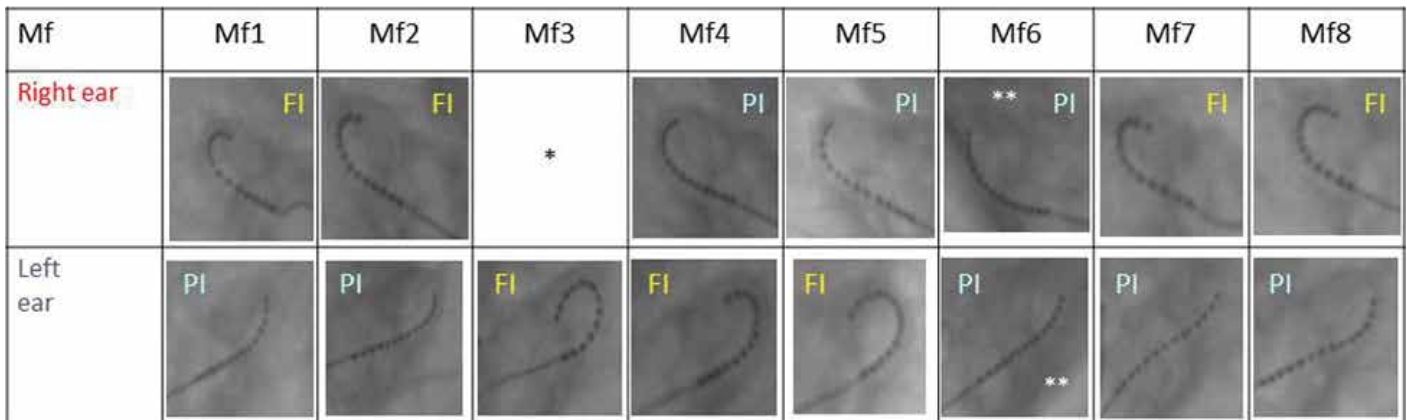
X-rays corresponding to the 16 ears after six months of follow-up.
